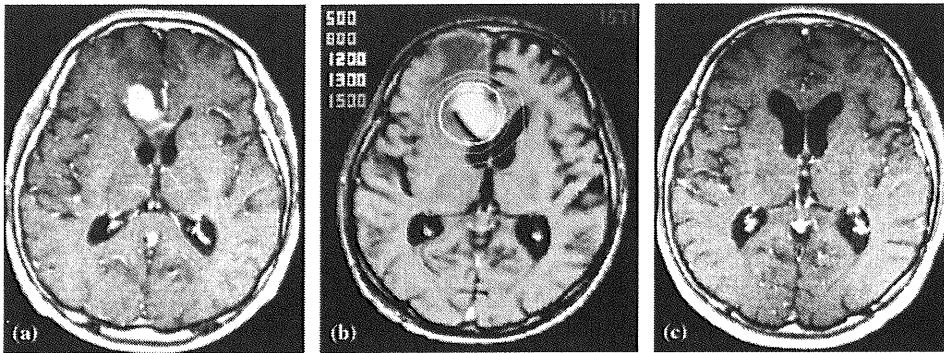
A case with recurrent PCNSL treated with SRS. A 51-year-old man with multiple intracranial recurrent tumors approximately one year after initial treatment. At first, several courses of salvage chemotherapy were attempted, but two of the tumors were resistant to chemotherapy (rt. frontal lobe and brain stem). Cranial nerve palsy and gait disturbance were progressive. Palliative SRS was performed at a prescription dose of 10 Gy. (a) MR image at the time of SRS, (b) treatment planning, (c) MR image three months after SRS.
